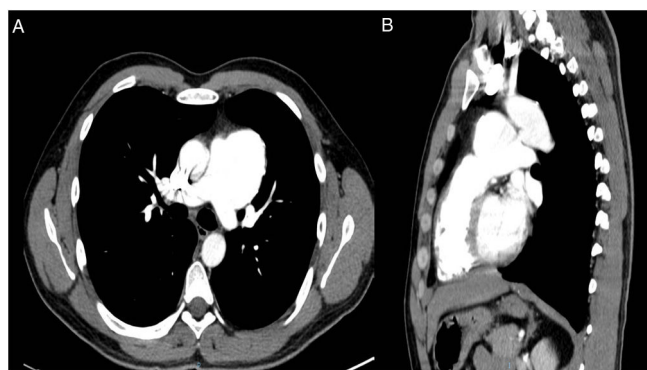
Contrast enhanced multislice chest CT (A) axial and (B) sagittal slices, showing an aneurysmal dilation arising from the pulmonary artery and wide patent ductus arteriosus.
